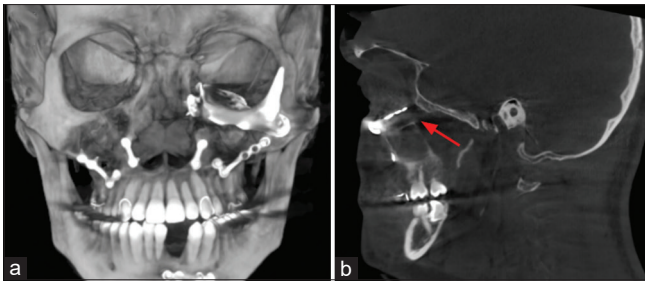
(a) Post operative CT showing orbital implant in place and (b) Red arrow showing improved orbital floor contour.
